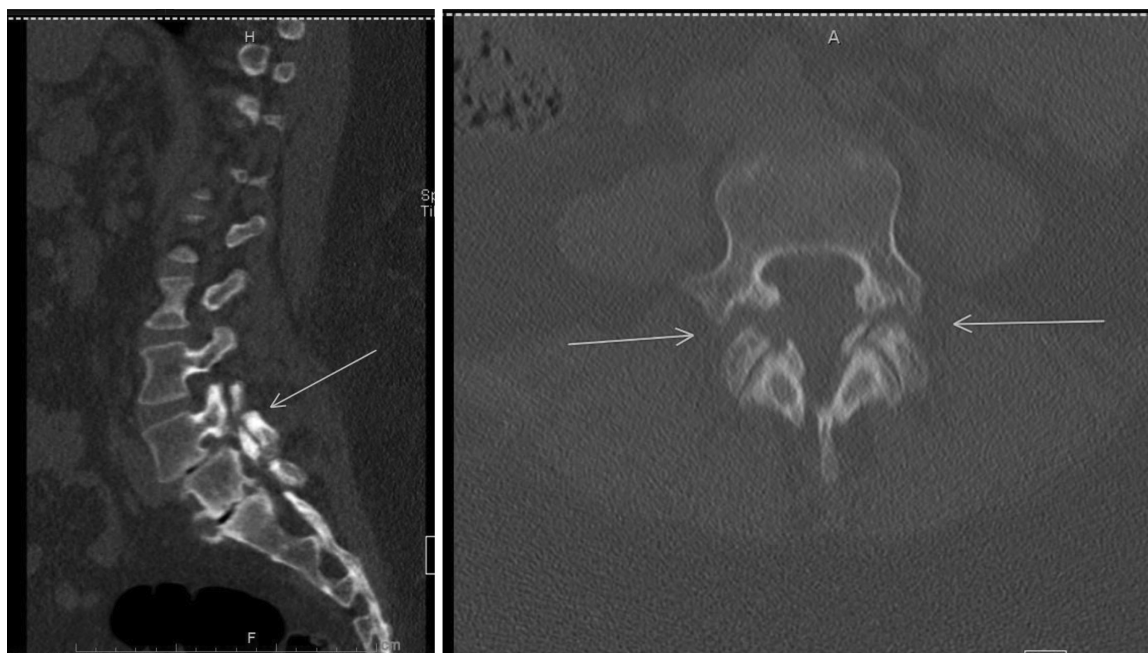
Sagittal and axial computed tomographic scans of the lumbar spine—Arrows denote bilateral pars defects of L5.
